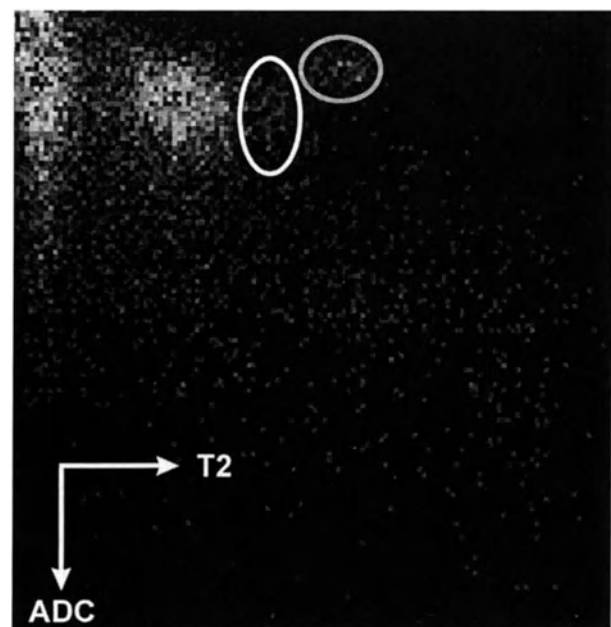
Histogram of the intensities of a T2-weighted image and a corresponding ADC-map: the edema core (grey) and rim (white) are segmented. The frequencies of intensity pairs are represented in a grey level coded manner (white = high frequencies, dark grey = low frequencies)
